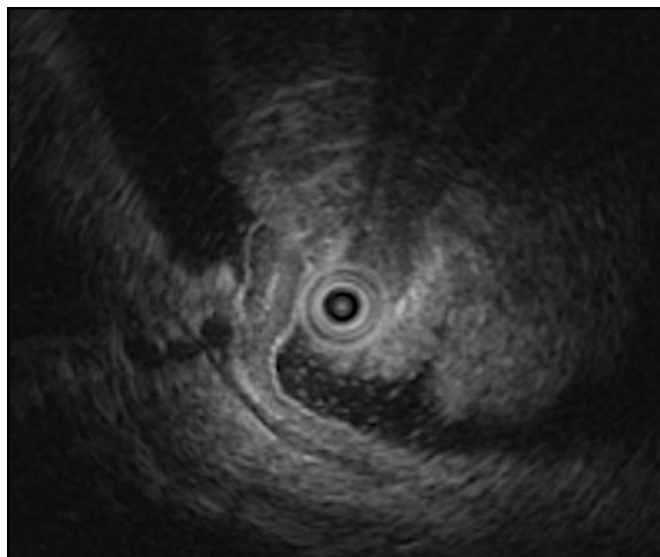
Endoscopic ultrasonographic image.
